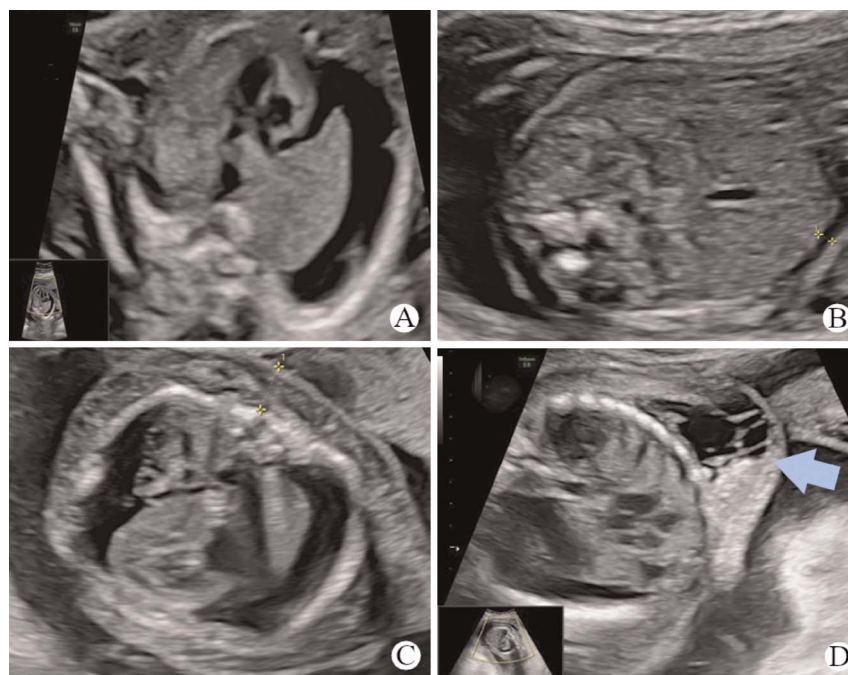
Two-dimensional ultrasound images of the fetus before and after intrauterine transfusion. A&B The upper panel shows ultrasound images of the fetal thorax (A) with right-sided hydrothorax and the fetal abdomen (B) with minimal fetal ascites before IUT. C&D The lower panel images from subsequent scans (after IUT) depict bilateral hydrothorax (C) and the appearance of axillary lymphatic masses (D), indicated by the arrow. IUT: Intrauterine transfusion.
